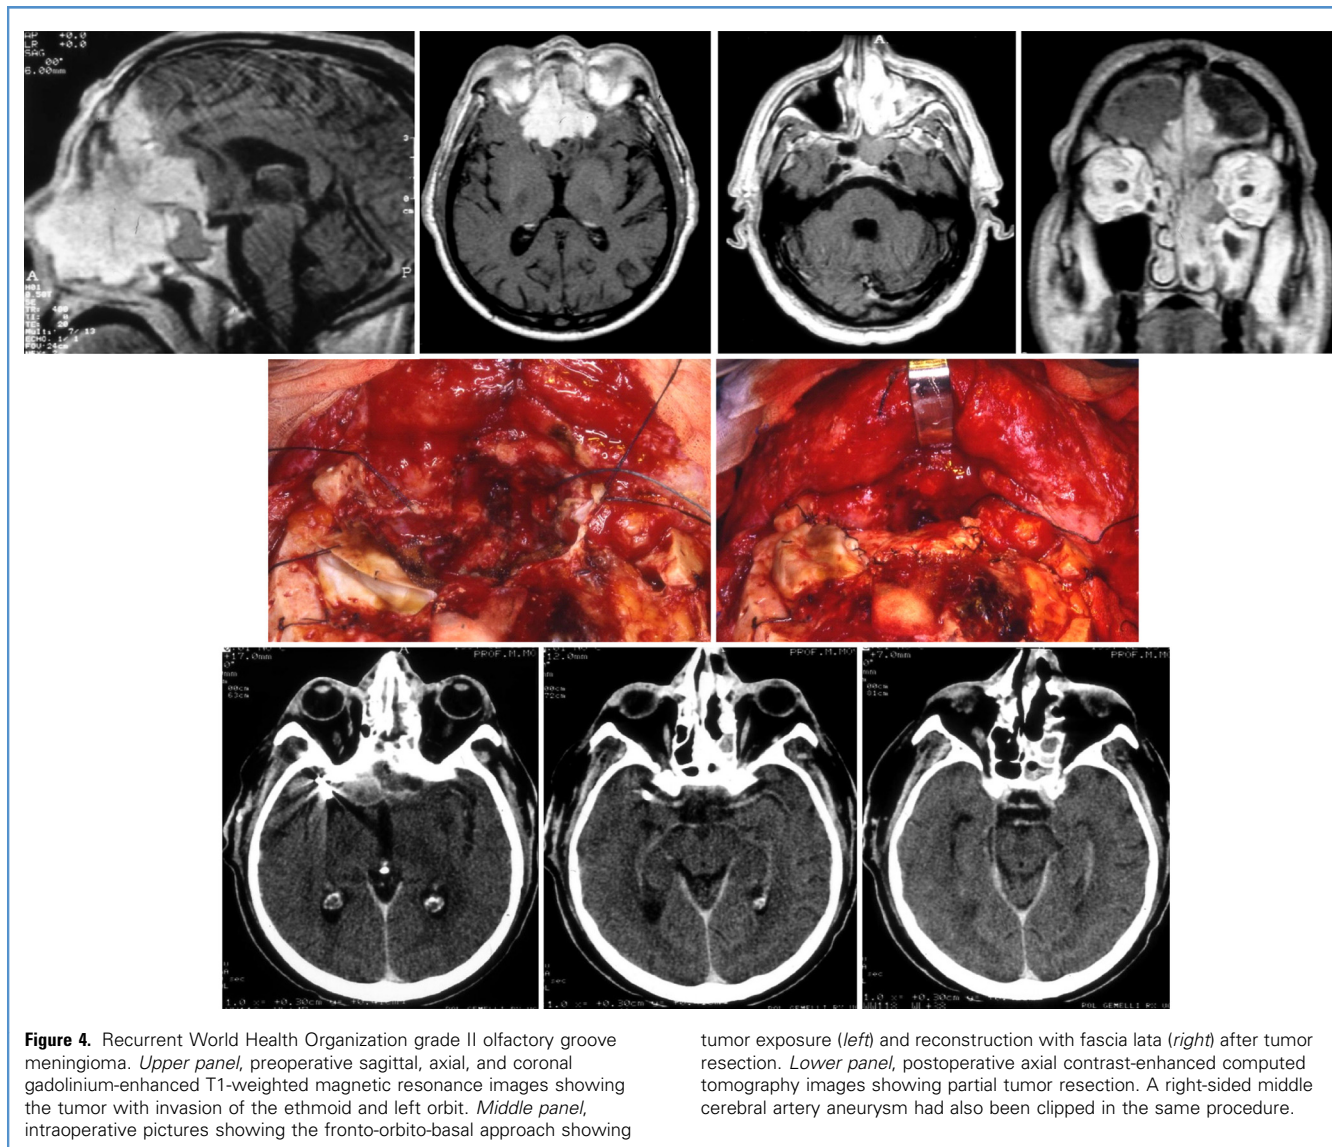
Recurrent World Health Organization grade II olfactory groove meningioma. *Upper panel*, preoperative sagittal, axial, and coronal gadolinium-enhanced T1-weighted magnetic resonance images showing the tumor with invasion of the ethmoid and left orbit. *Middle panel*, intraoperative pictures showing the fronto-orbito-basal approach showing
